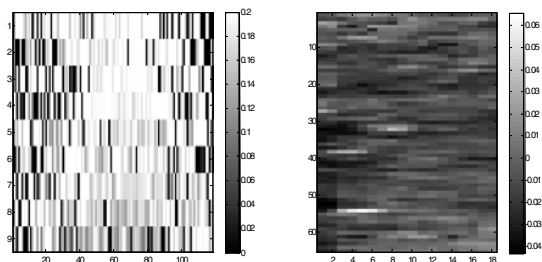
Local strain map parallel to compression (left) and the corresponding strain map perpendicular to compression (right) obtained from ultrasound elastography, with intensity indicating strain.
